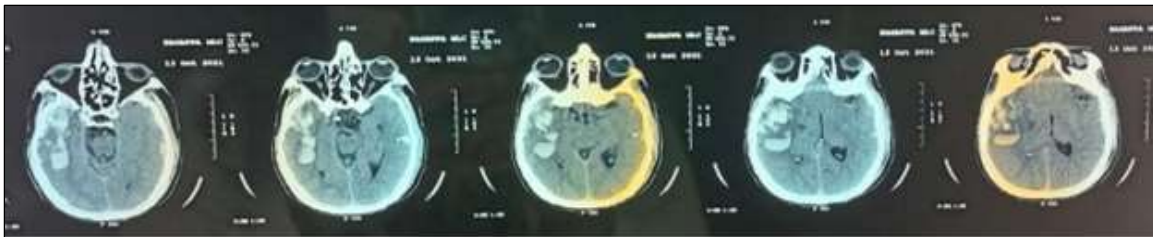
Pre-operative CT scan showing temporal ICH
